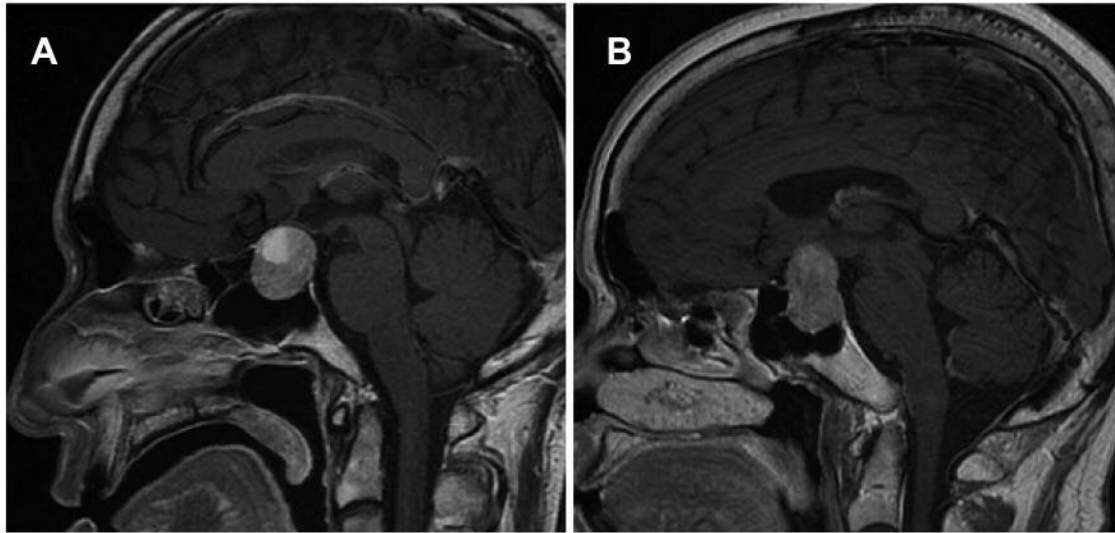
MR images of pituitary apoplexy. MR images were obtained before surgery. A: Case 2: A patient with pituitary apoplexy. T1-weighted gadolinium-enhanced MRI (sagittal image) shows fresh blood associated with fluid-fluid level formation within the tumor. B: Case 6: A patient without pituitary apoplexy. T1-weighted gadolinium-enhanced MRI (sagittal image) shows the pituitary tumor without apoplexy.
